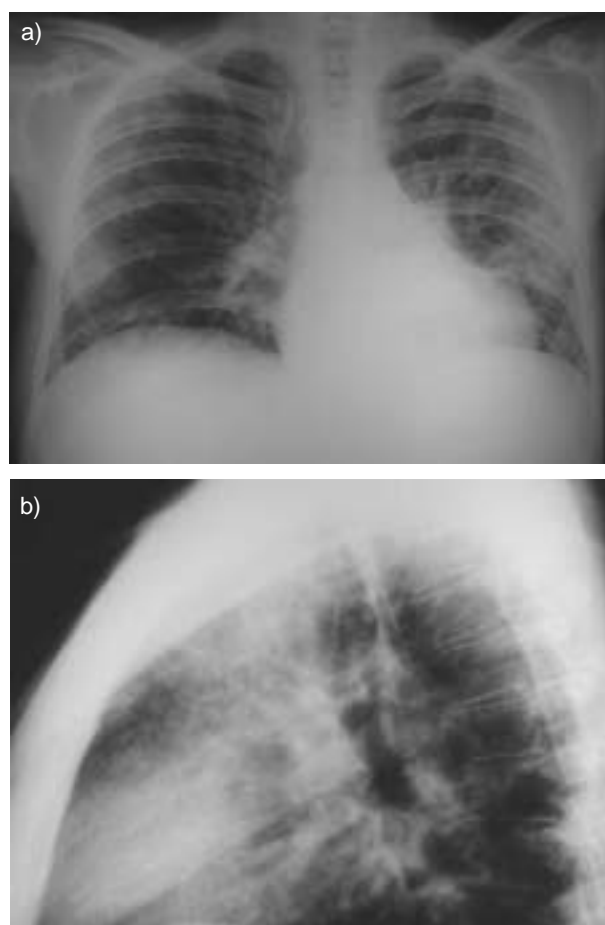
Chest radiography a) posteroanterior and b) lateral view.
